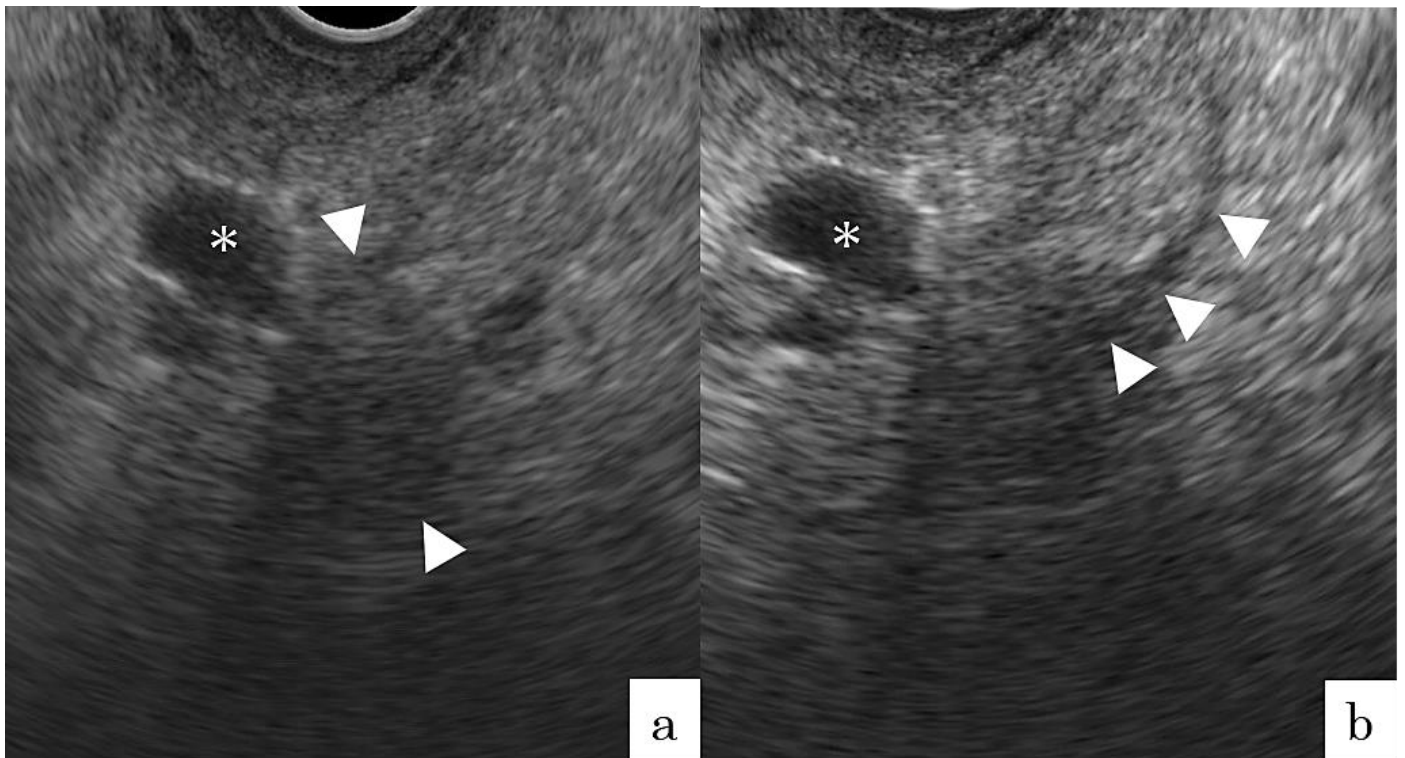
Endoscopic ultrasonography in Case 2.
